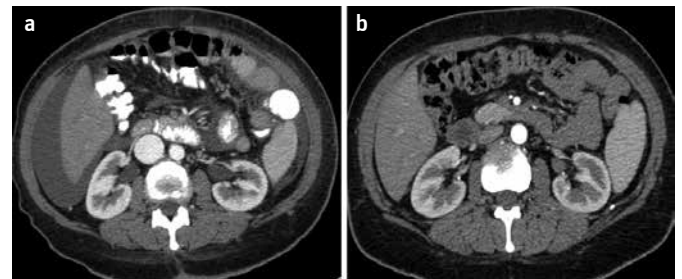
a, b. Peritoneal fluid excess in abdomen and dilated inferior vena cava identified by CT (a). Intra-abdominal fluid and vena cava dilatation was seen marked improvement after left iliac artery stenting (b).
